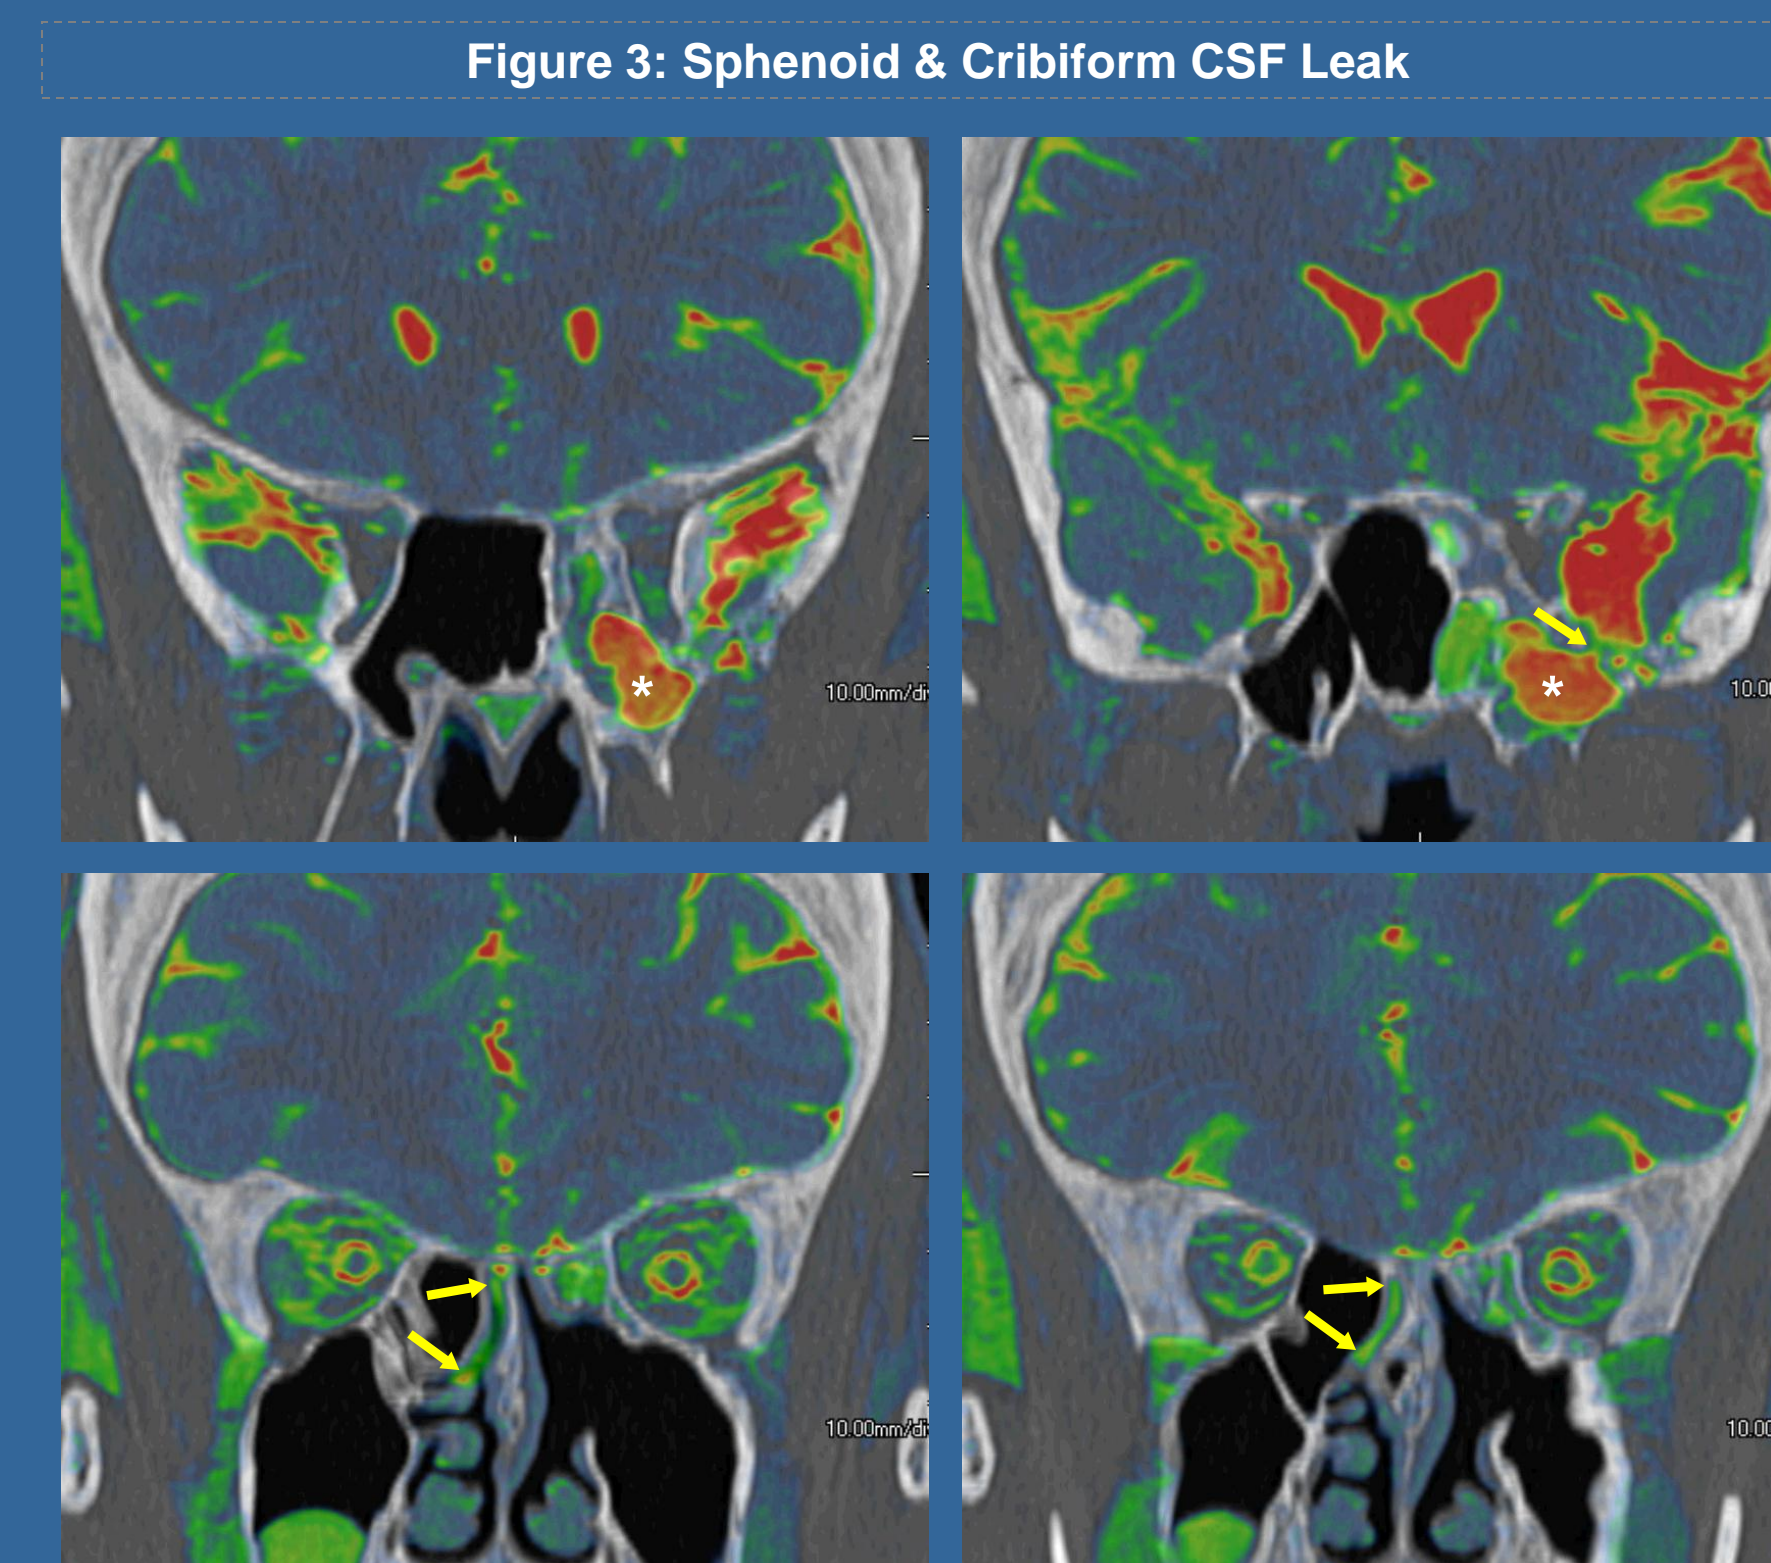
Coronal fused CT-MR images in a patient with multiple prior sinus procedures including prior CSF leak repair. Fluid pools in the left sphenoid sinus (asterisk in A&B) from site of previous leakage (arrow in B). Patient developed a new site of CSF leakage through the right cribiform region with fluid projecting inferiorly from the right olfactory recess (arrows in C & D).
